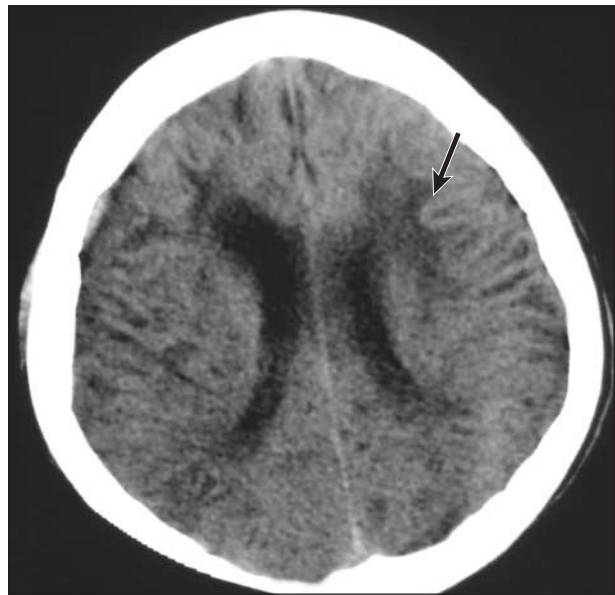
Computed tomographic image of the brain. Brain atrophy is present with hypodense bilateral subcortical white matter lesions. Note the sharp delimitation of the corticosubcortical junction (arrow).
